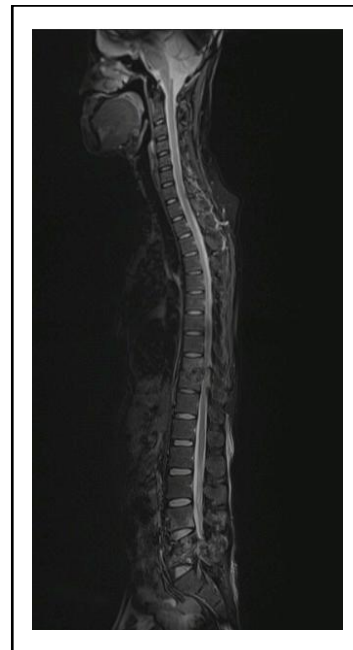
MRI Whole Spine T2 Non-Kontras
